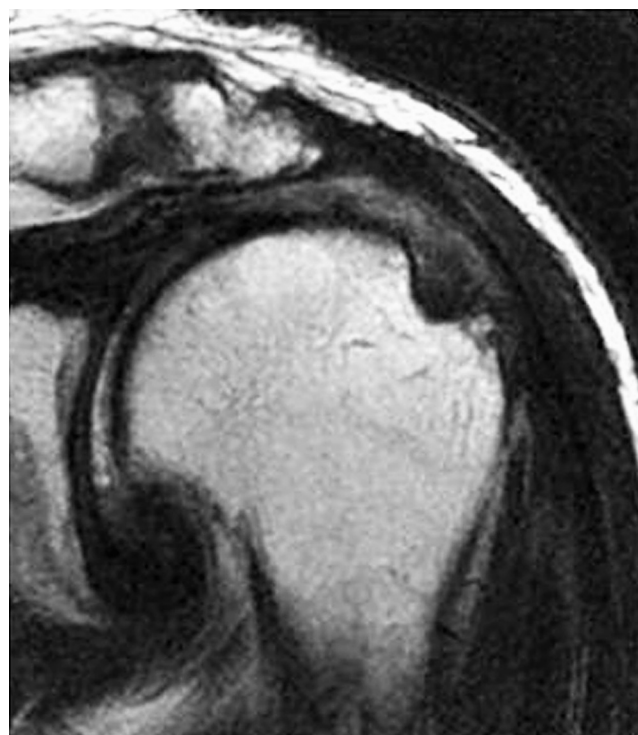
Magnetic resonance imaging finding 1 year after surgery.
